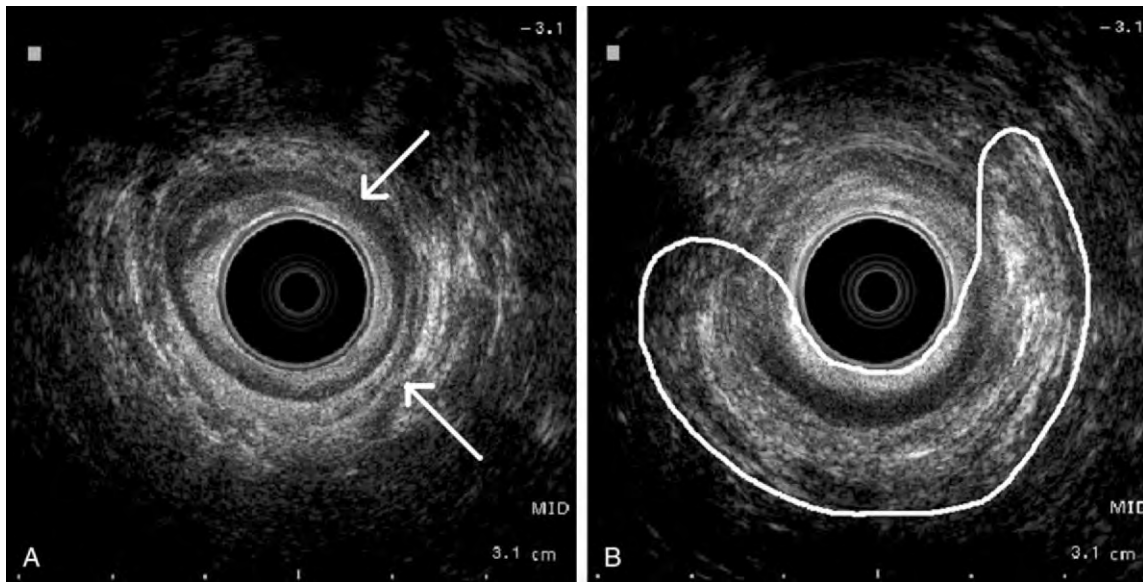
Endoanal ultrasound. A, Normal sphincter, mid-anal canal: the *arrow* at 1 o'clock indicates the internal anal sphincter, and the *arrow* at 4 o'clock points to the external anal sphincter. B, Disruption of anterior internal and external anal sphincter muscles with posterior retraction of muscles. The *line* indicates retracted muscle.
